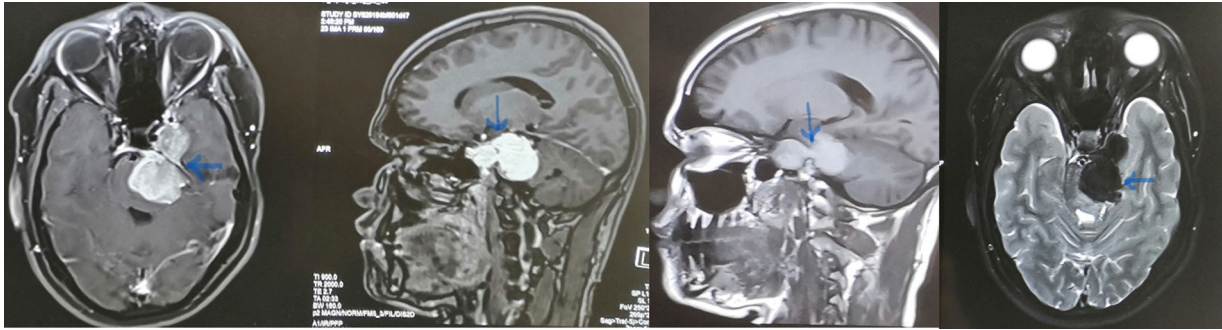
Recent sagittal T1-weighted images showing dumbbell-shaped hyperintense lesion (blue arrow), axial T2-weighted image showing hypointense lesion (blue arrow), and gadolinium contrast-enhanced images showing homogenous enhancement of lesion (blue arrows).
